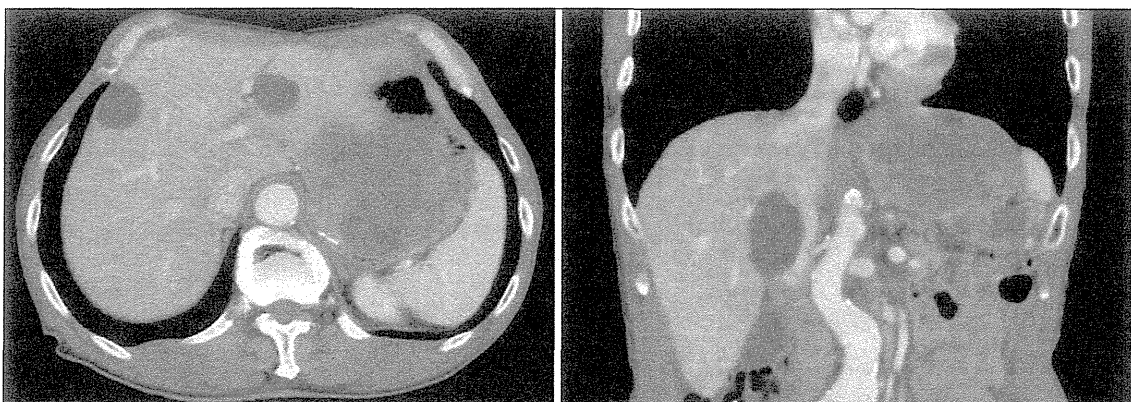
Abdominal enhanced CT revealed local recurrence of GIST, invaded lateral segment of the liver and the diaphragm.
